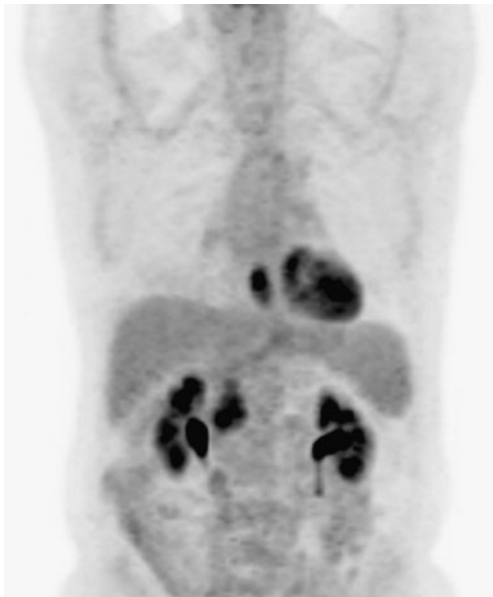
Maximum intensity projection of PET. Both the pancreatic and esophageal cancers exhibit increased FDG uptake
